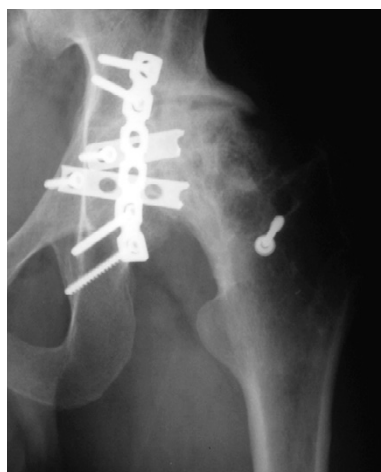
Anteroposterior plain radiograph at 12 months post-ACI showing residual metalwork in the acetabulum. Also, cysts and sclerotic areas of the femoral head can be seen clearly.
